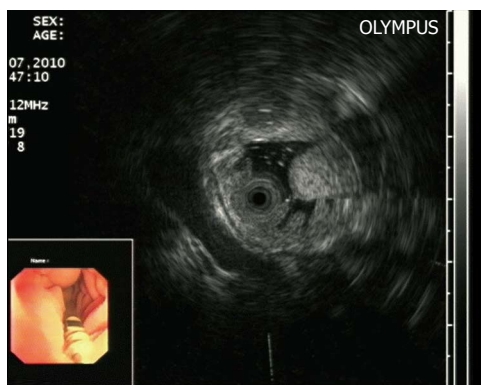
Endoscopic and endoscopic ultrasonography findings in Case 2. A: A submucosal tumor located in the descendant duodenum with a yellowish and soft appearance; B: Endoscopic ultrasonography showed an oval intensive hyperechoic lesion with homogeneous parenchymal echogenicity and a clear margin originating from the third layer without involvement of the overlying mucosal layers. Echo attenuation was seen at the area behind the focus.
